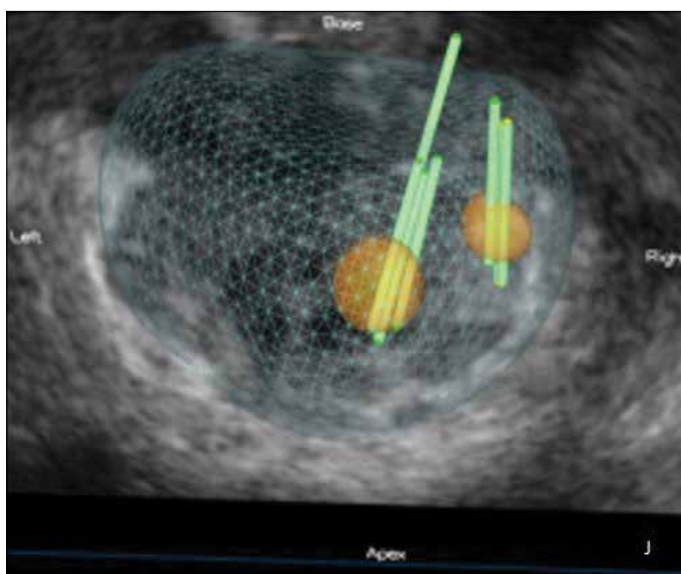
Mp-MRI for prostate cancer localization in the apex and in the right zone in a 60-year-old man. After these lesions were marked in fusion images, targeted biopsy was performed with exact accuracy
